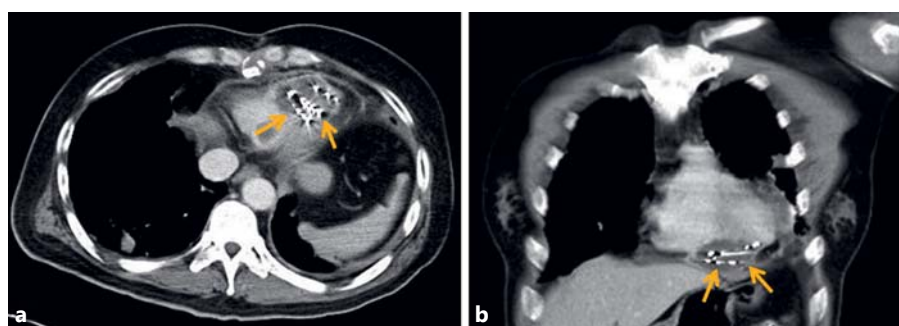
CT-enhanced scan images after 3 months. a Cross-section. b Coronal plane. Arrows indicate the implanted iodine seed. Ventricular lesions are slightly smaller than before treatment at approximately $4.7 \times 3.7 \times 2.9$ cm.
